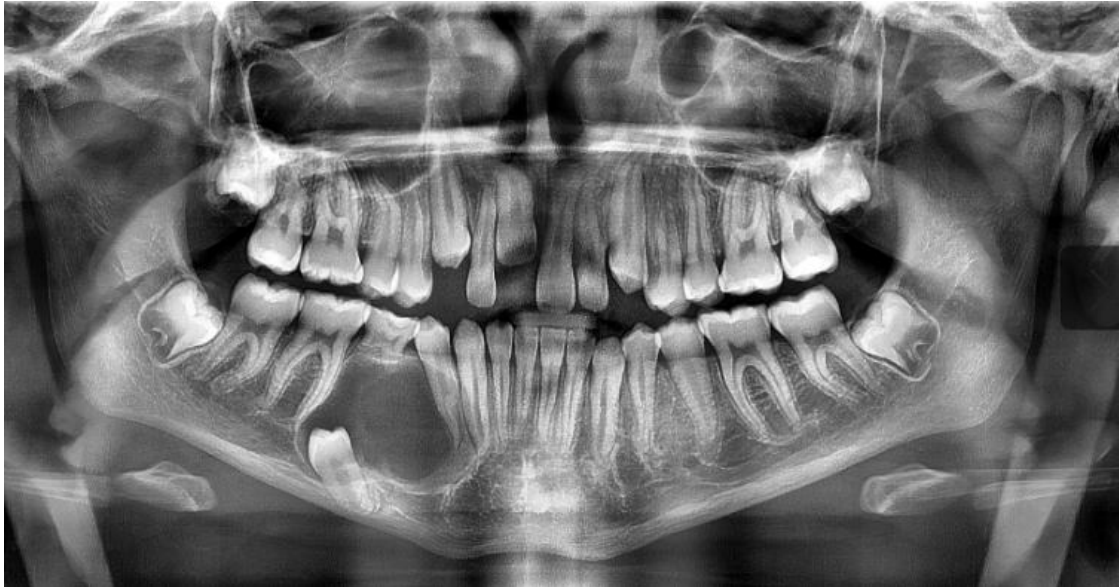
initial panoramic x-rays
